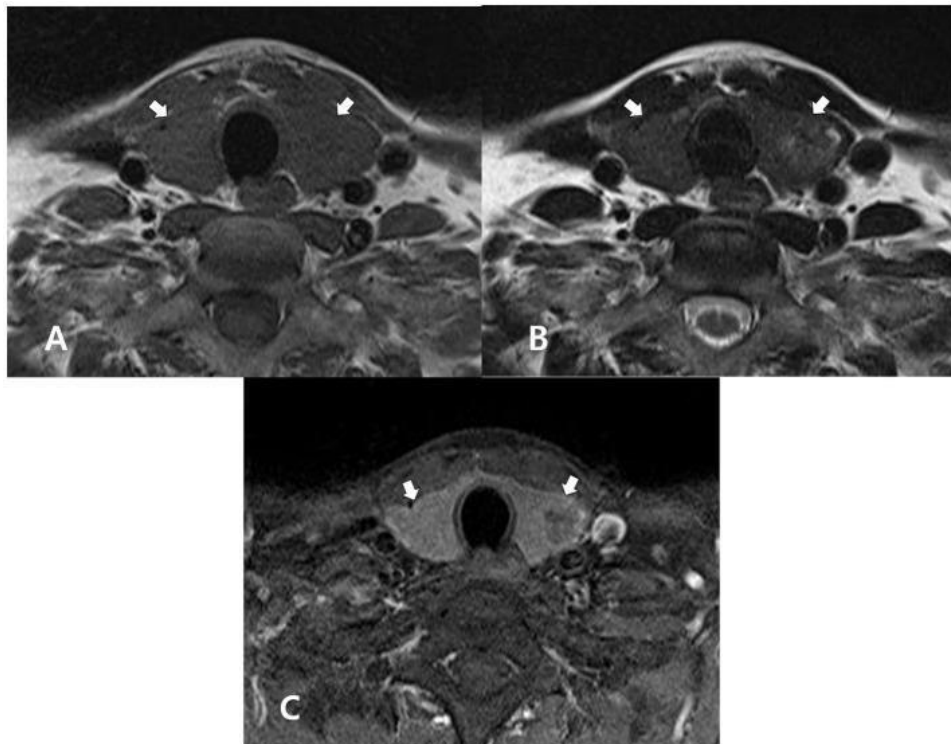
On MRI, normal thyroid parenchyma can be visible. When compared to nearby muscle, the thyroid gland (arrows) exhibits homogenous, isointense and somewhat elevated signal intensities in non-enhanced axial T1(A) and T2(B) weighted images. The thyroid gland (arrows) is typical in size and has a smooth border in both the images. When compared to nearby muscle in the enhanced axial, fat-suppression T1-weighted picture (C), the thyroid gland (arrows) demonstrates homogeneously greater enhancement.¹⁴
